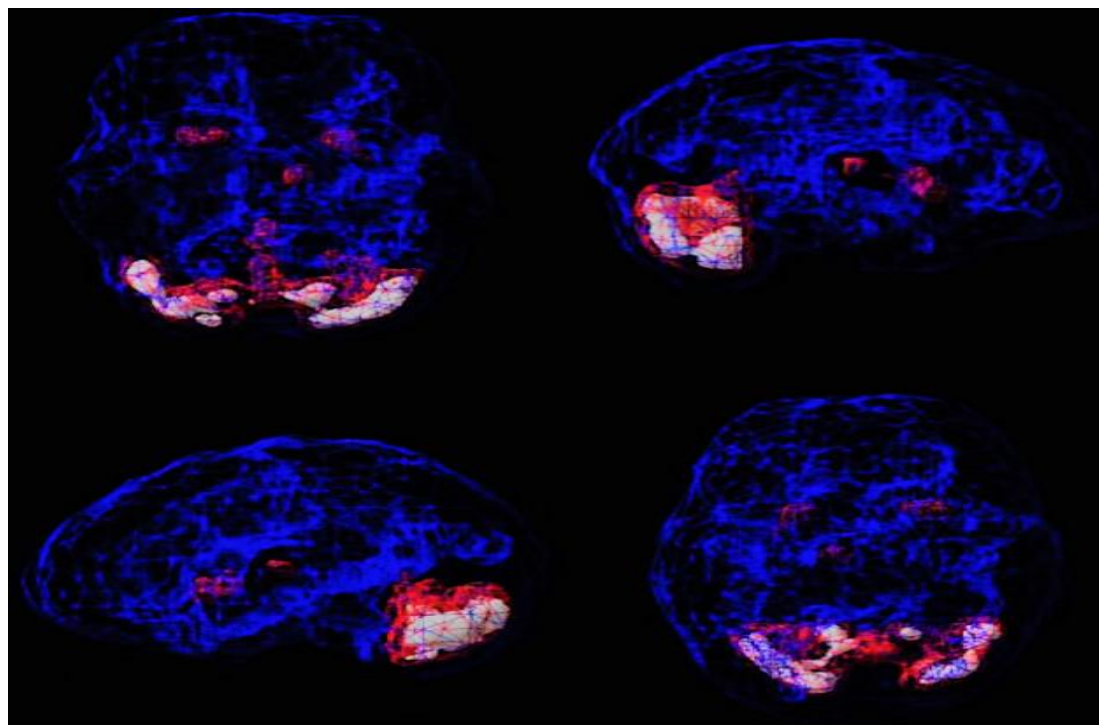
Indicates a strong 3D dynamic depiction of SPECT data, with improved perfusion regions highlighted. Blue represents common or average perfusion, the color red represents the top fifteen percent of perfusion, plus white represents the peak 7 or 8%. Outside the cerebellum, the commotion over these levels is 2 to 3 (SD) standard deviations more than regular (10). Increased perfusion in the cerebellum is shown in a healthy active MRI with HMPAO [19].
